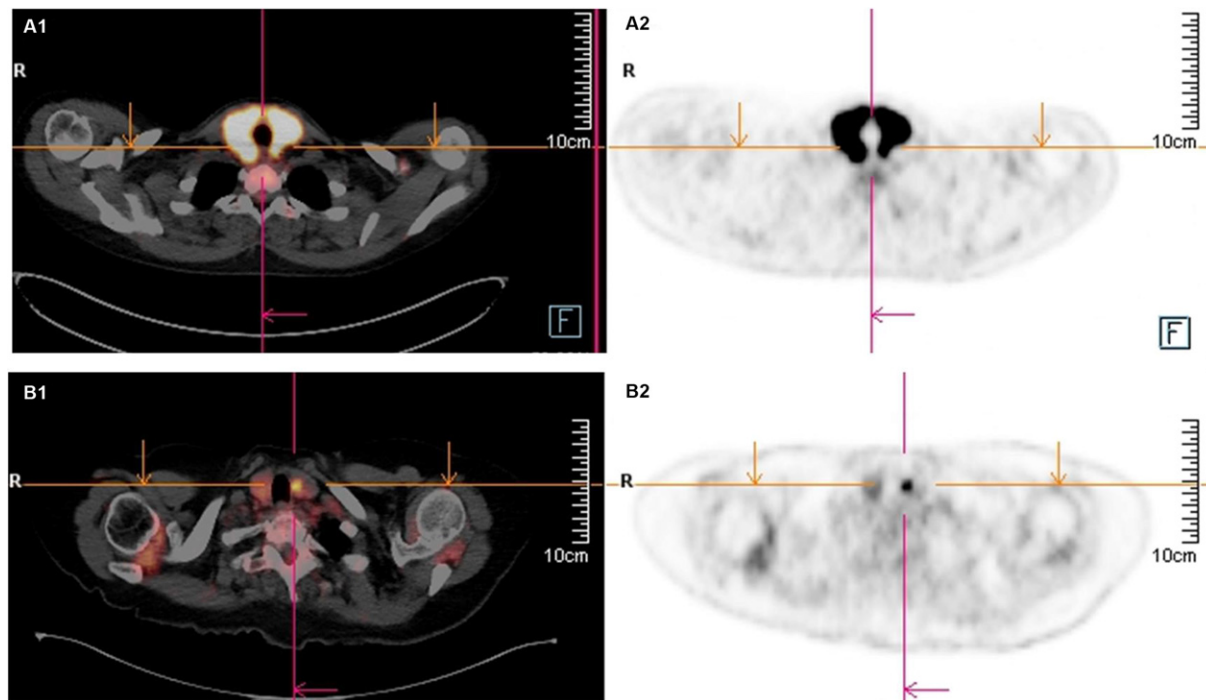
Axial ^{18}F -FDG PET/CT (A1, B1) and PET (A2, B2) images showing diffuse (A1, A2) and focal (B1, B2) patterns of incidental ^{18}F -FDG uptake in the thyroid gland in two oncological patients evaluated by ^{18}F -FDG PET/CT for non-thyroid tumors.
